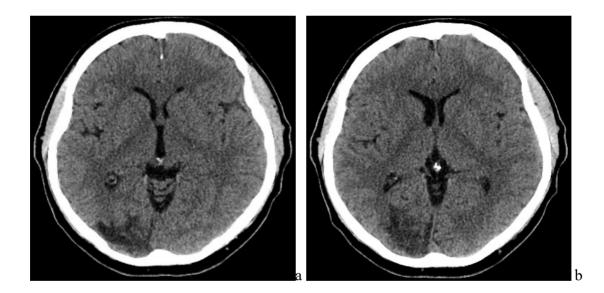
MRI of the Brain transverse plane (a,b). Coronal plane (c).
